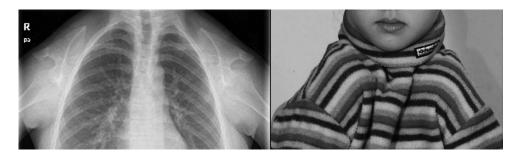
Chest posteroanterior radiograph and clinical photograph of case 9 (8 years 2 months). Because of aplasia of the clavicles, this patient can bring both shoulders closer together than normal individuals.
